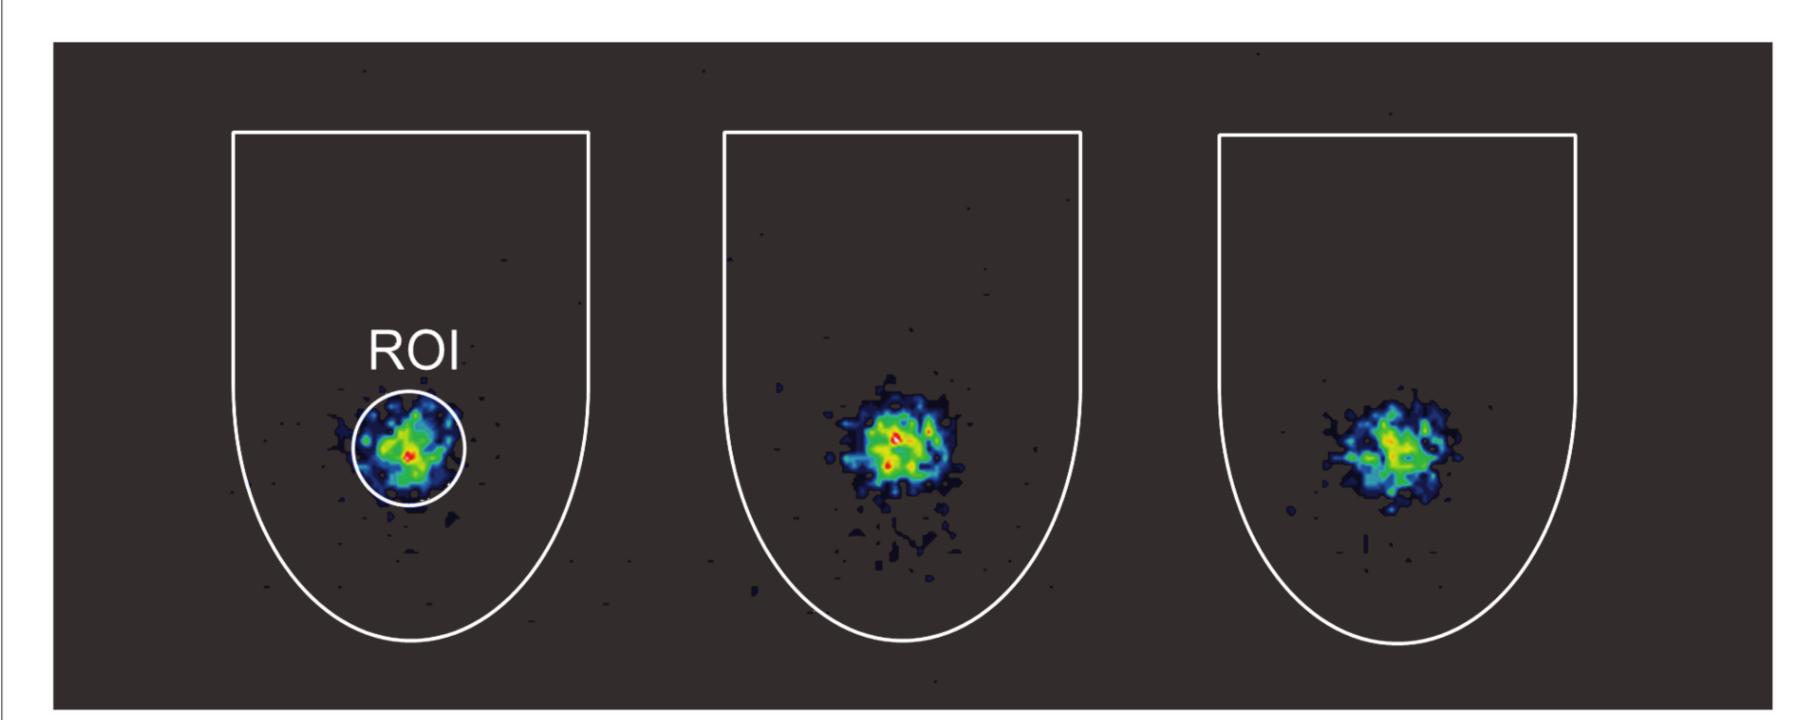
Gamma scintigraphic image during dissolution of radioactive placebo pellets at t=2 h. An ROI and the dissolution vessels are drawn on the image.
